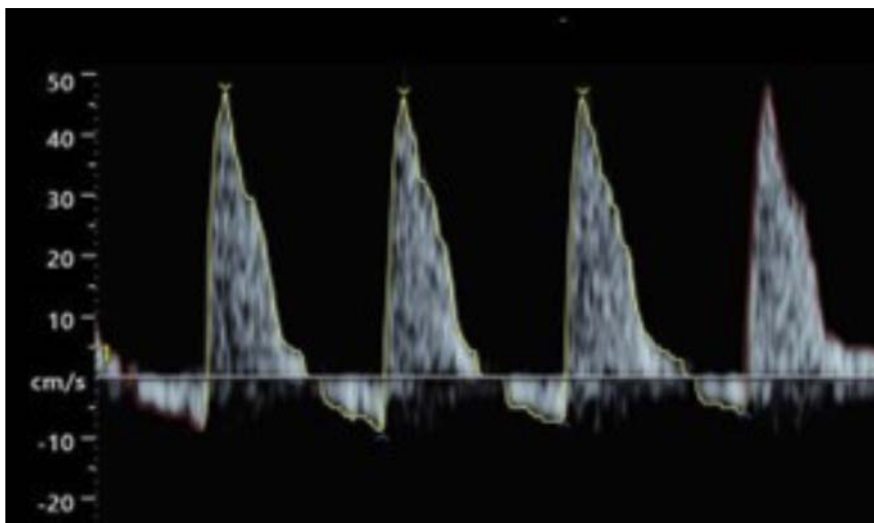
Doppler examination of the middle cerebral artery with presence of reverse flow
